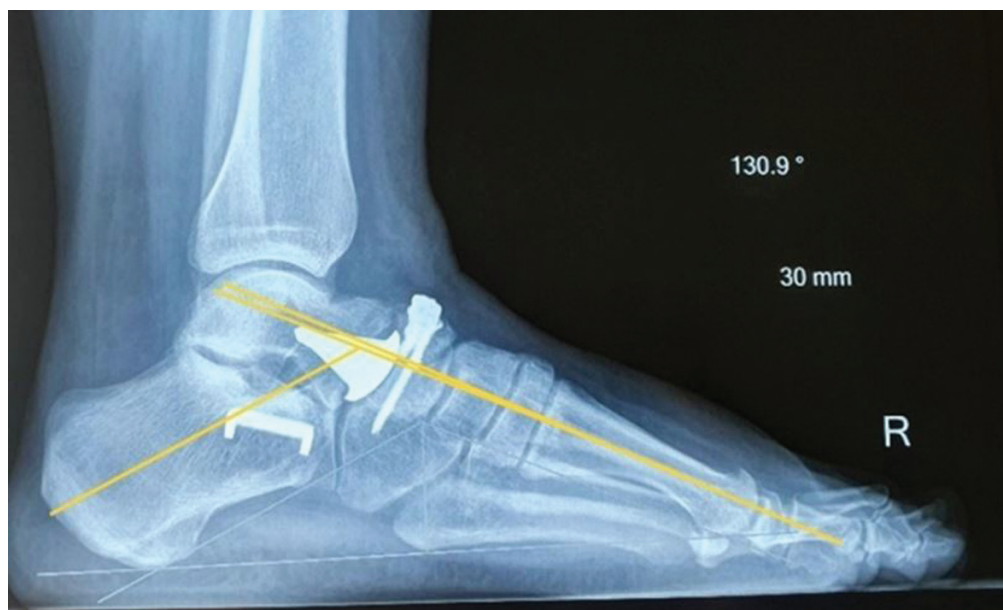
Weight-bearing lateral radiograph of the right foot at 12 months showing no signs of migration with neutral physiological position of the foot; Mary angle of 2°, Kite talocalcaneal angle of 50°
